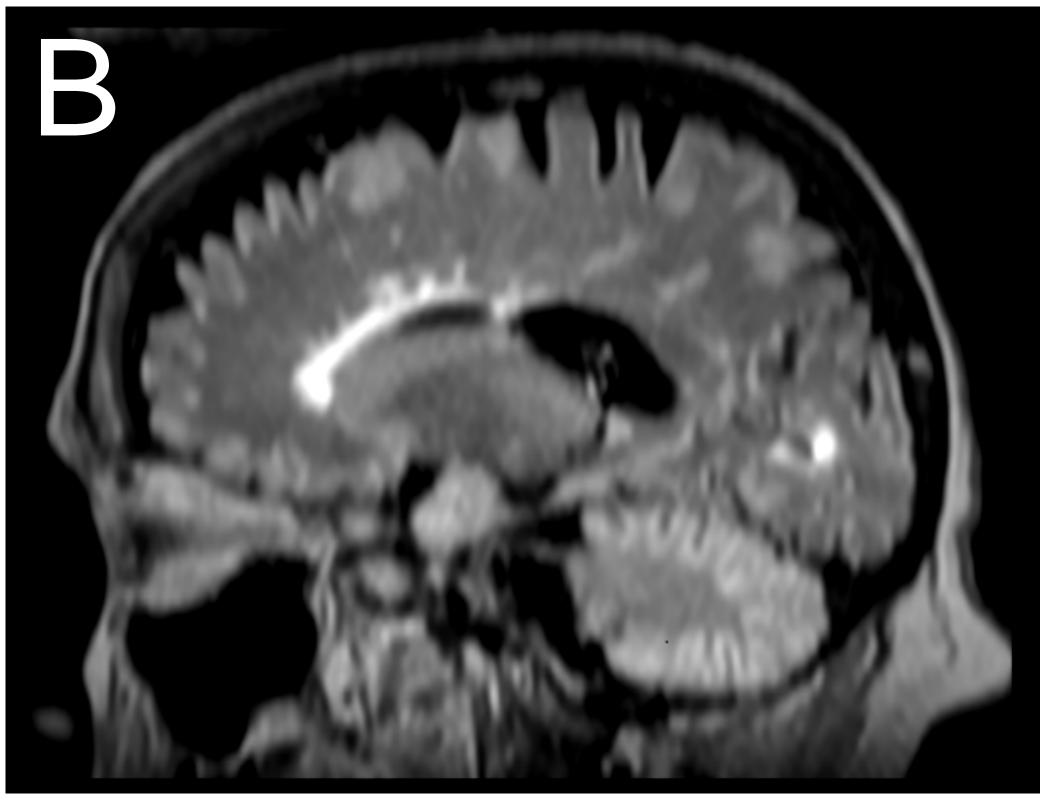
A) Axial and B) sagittal views of MRI brain (T2 and FLAIR) obtained during hospitalization demonstrating multiple supratentorial white matter signal abnormalities, some of which have a septocallosal pattern of distribution without enhancement.
